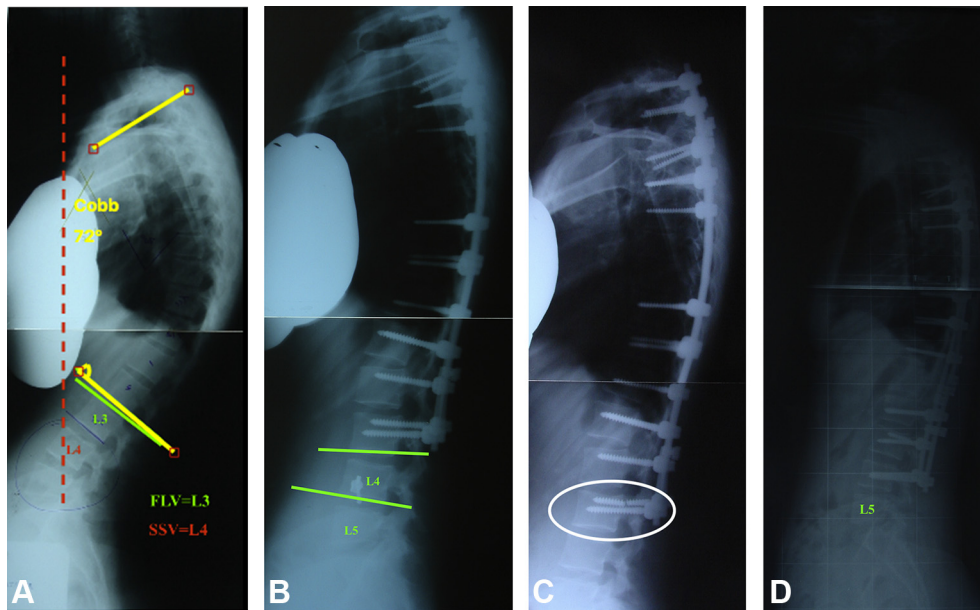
Twenty year-old women with SK. A – Preoperative lateral X-ray shows that FLV is L3 and SSV is L4. The patient was operated through a posterior approach through T2-L3. B – After 1 month DJK was observed. C – Six months later distal screw was broken (white circle). D – Because of being symptomatic, the instrumentation level extended to L4, which was the SSV preoperatively.
